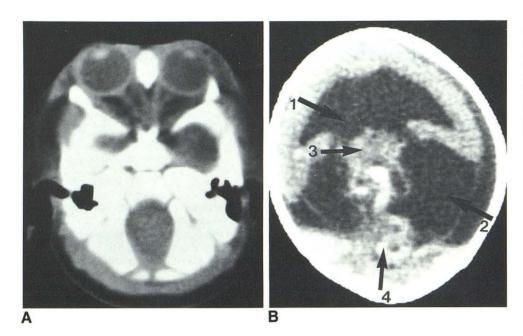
CT scans. A, Medial fusion of orbits. Ethmoid air cells are absent. Optic nerves are incompletely divided and fuse before entering single optic canal. B, At level of midcranium. Anteriorly, single ventricle (arrow 1) is surrounded by undivided brain substance. Parts of cerebrospinal fluid-filled dorsal sac (arrow 2). Undivided thalamus (arrow 3); enlarged and serpiginous vein of Galen after contrast enhancement (arrow 4).
